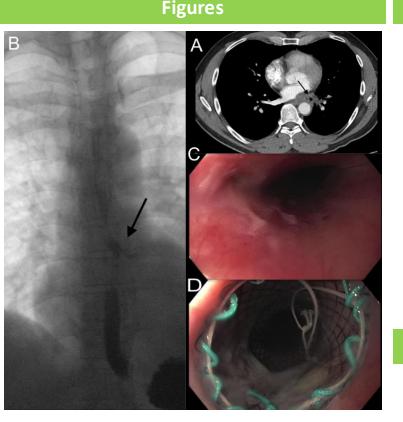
Computed tomography (CT) chest with intravenous contrast showing mild thickening in the left posterior aspect of the left atrium, tiny pockets of air in the left infrahilar region (arrow).
